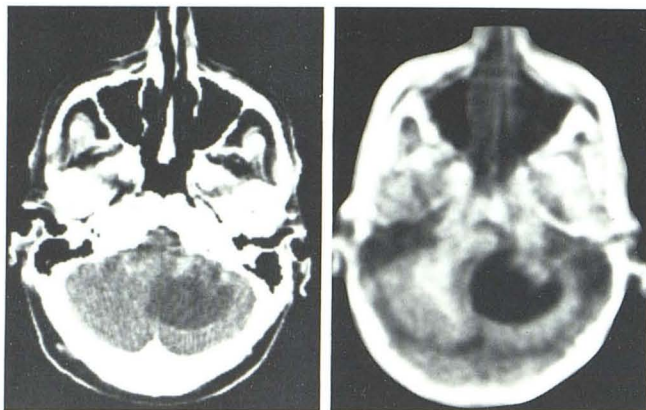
Glioma. A, CT. B, IR_{1400/400}. Lighter area within tumor possibly represents hemorrhage. Displacement of brainstem well seen.
